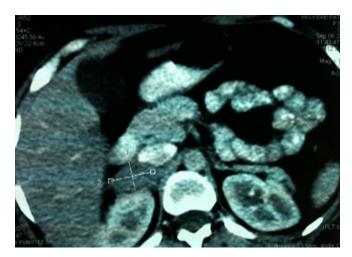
adrenal lesion on the CT scan.
